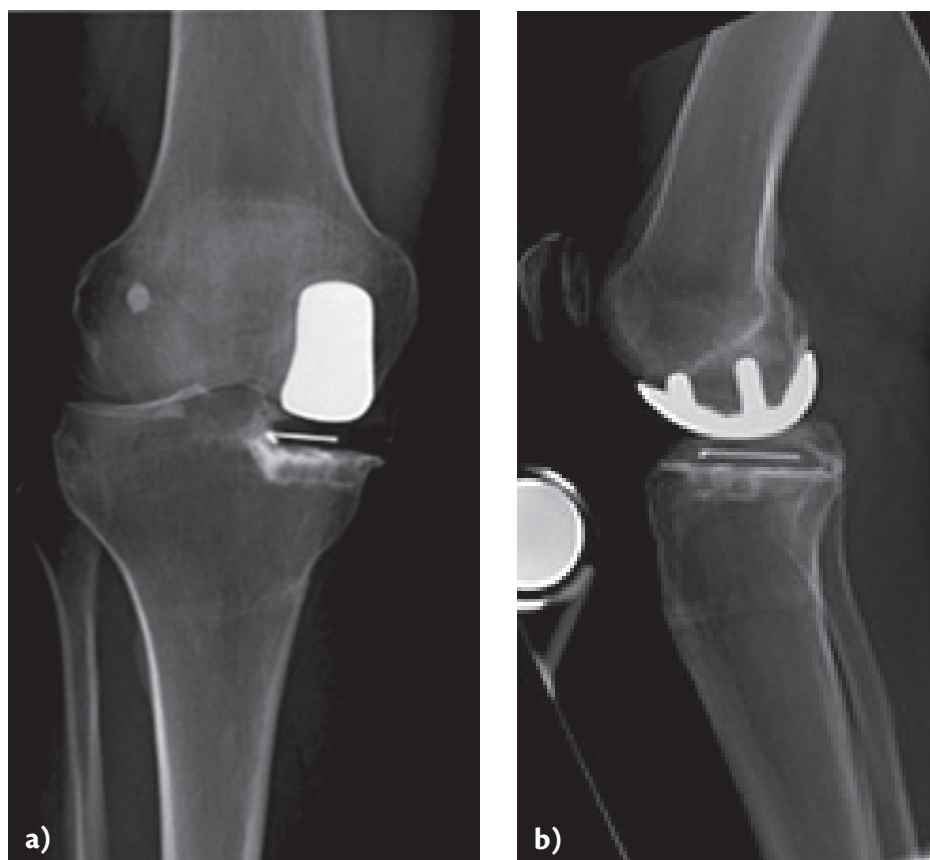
Unicompartamental knee replacement (also called a partial knee replacement) in the medial compartment of the knee joint. a) X-ray, front view; b) X-ray, side view.
